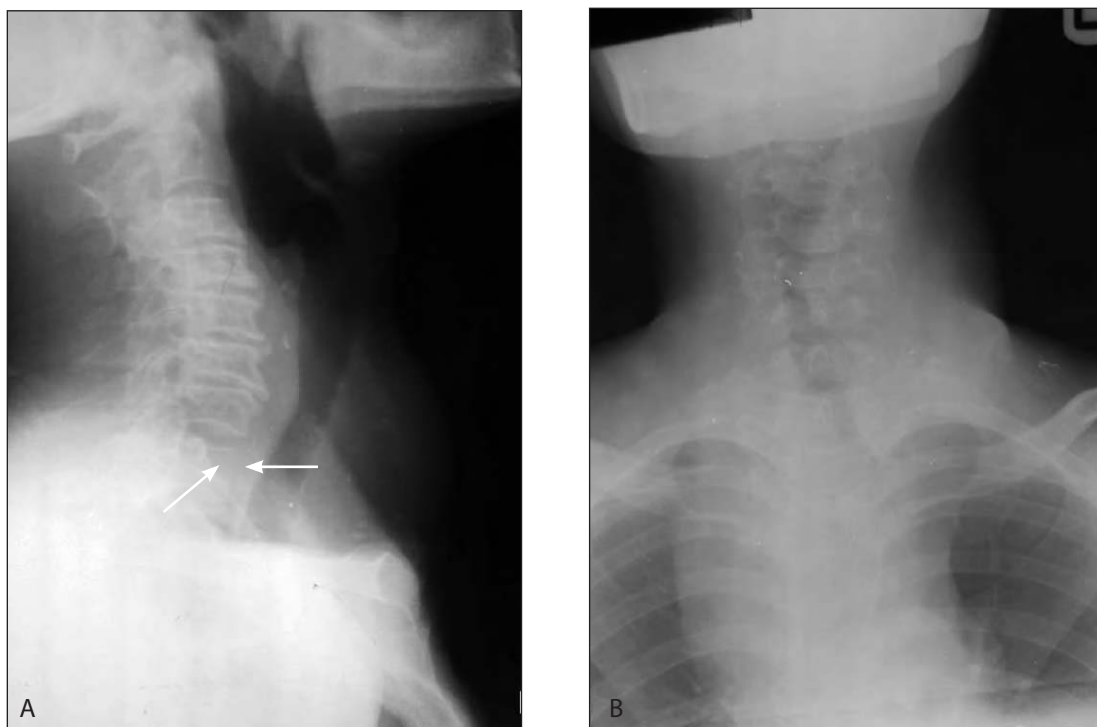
Lateral neck and frontal thoracocervical radiographs of a patient with malignant goitre having retrosternal extension. [A] Showing wide spread nodular calcifications in goitre, cervical osteophytes and erosion of the anterior body of T1 and [B] retrosternal extension with tracheal deviation
